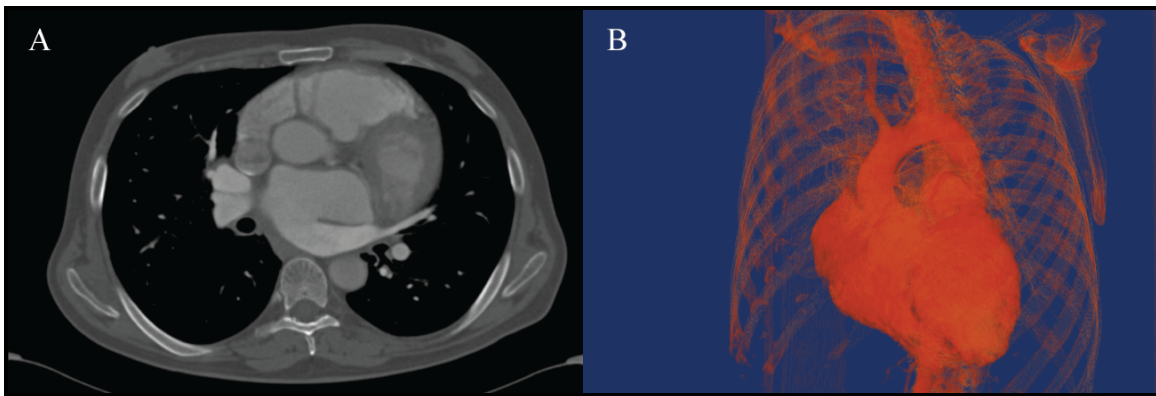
Contrast-enhanced CT scan of a CHD patient. Figure 6B: A DVR reconstruction developed from the CT scan.
